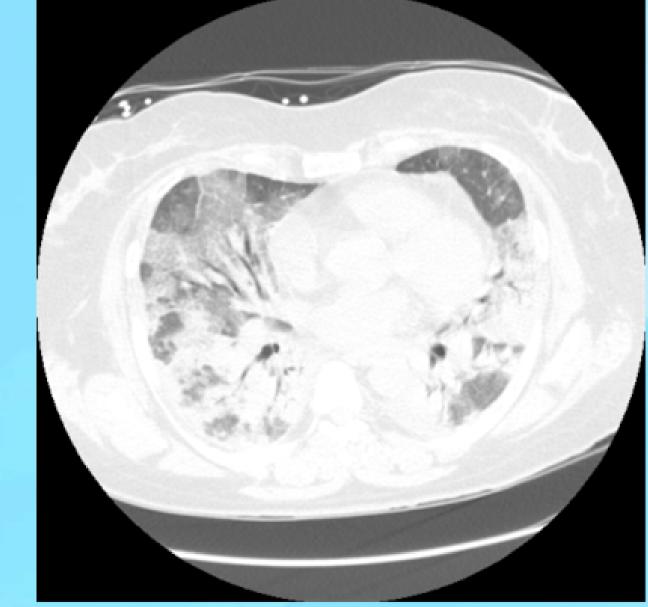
Patient's CT Scan showing bilateral lower lobe consolidation and diffuse groundglass opacities.
